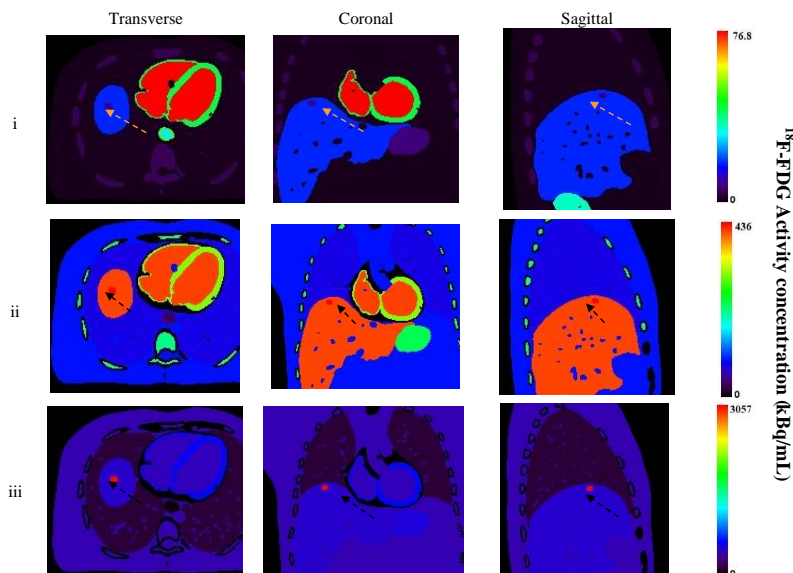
Transverse, coronal and sagittal images of <sup>18</sup>F-FDG activity maps taken at 3 different time points corresponding to : i = frame 1, ii = frame 17 and iii = frame 28. The arrow shows the lesion inserted in the liver
